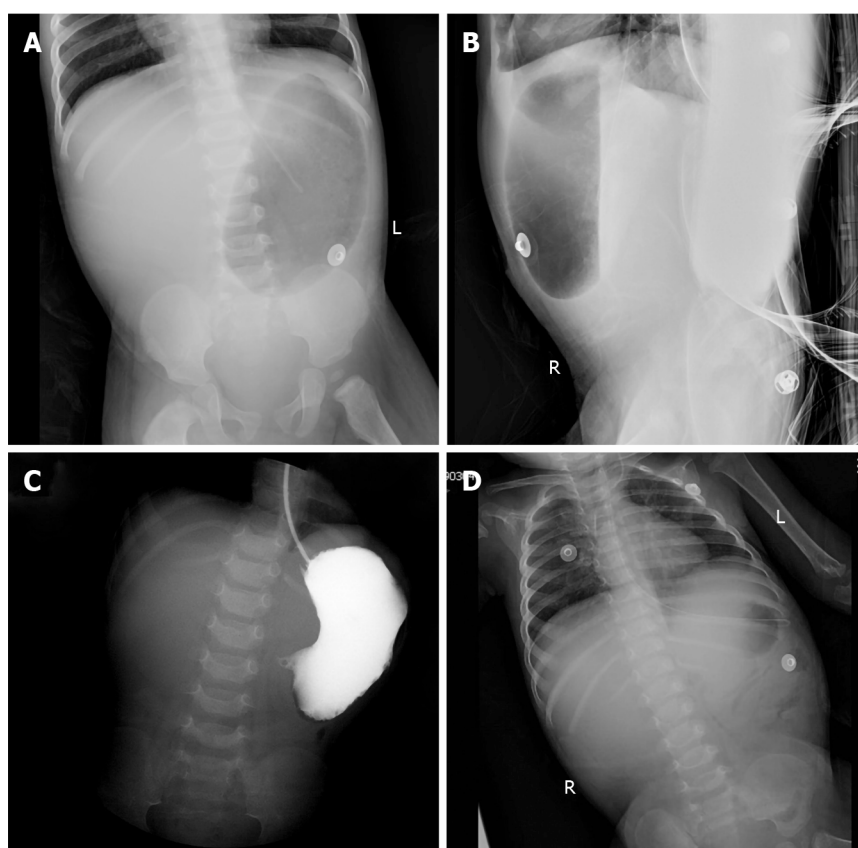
Abdominal plain. A and B: Supine (A) and lateral (B) abdominal plain films showed a large stomach, and no free gas was found in the small intestine, colon, or rectum. A nasogastric tube was coiled in the stomach; C: The iopromide administered by gastric tube did not enter the duodenum; D: Re-examination of abdominal film revealed decreased gas in the stomach and a few inflatable intestines.
